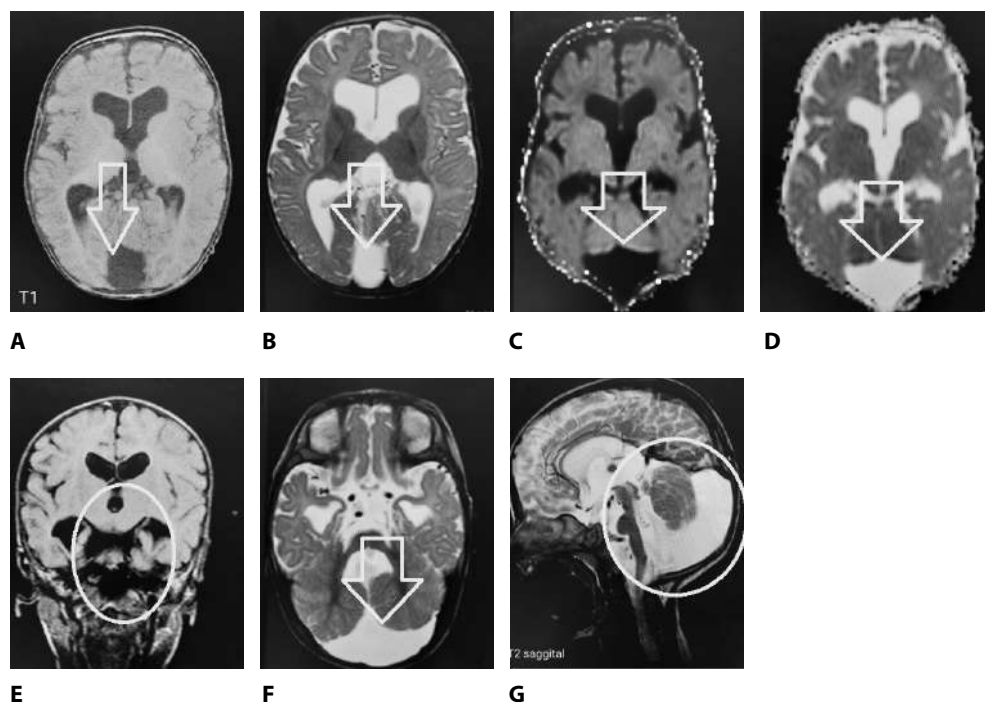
8 months new baby (Dendy) Walker malformation: is a posterior fossa anomaly characterized by agenesis or hypoplasia of the vermis and cystic enlargement of the fourth ventricle causing upward displacement of tentorium and torcula): A. T1WI axial: Large posterior fossa cystic space continue with the 4th ventricle, hypoplastic vermis. B. T2WI axial: Large posterior fossa cystic CSF spaces continue with 4th ventricle, obstructive hydrocephalus, hypoplasia of vermis. C. DWI: free diffusion. D. ADC map. E. FLAIR coronal: signal drop of CSF spaces. F. T2 axial: large posterior fossa cystic CSF spaces continue with 4th ventricle, obstructive hydrocephalus, hypoplasia of vermis. G. T2WI sagittal: abnormally high tentorium by cystic enlargement of posterior fossa
